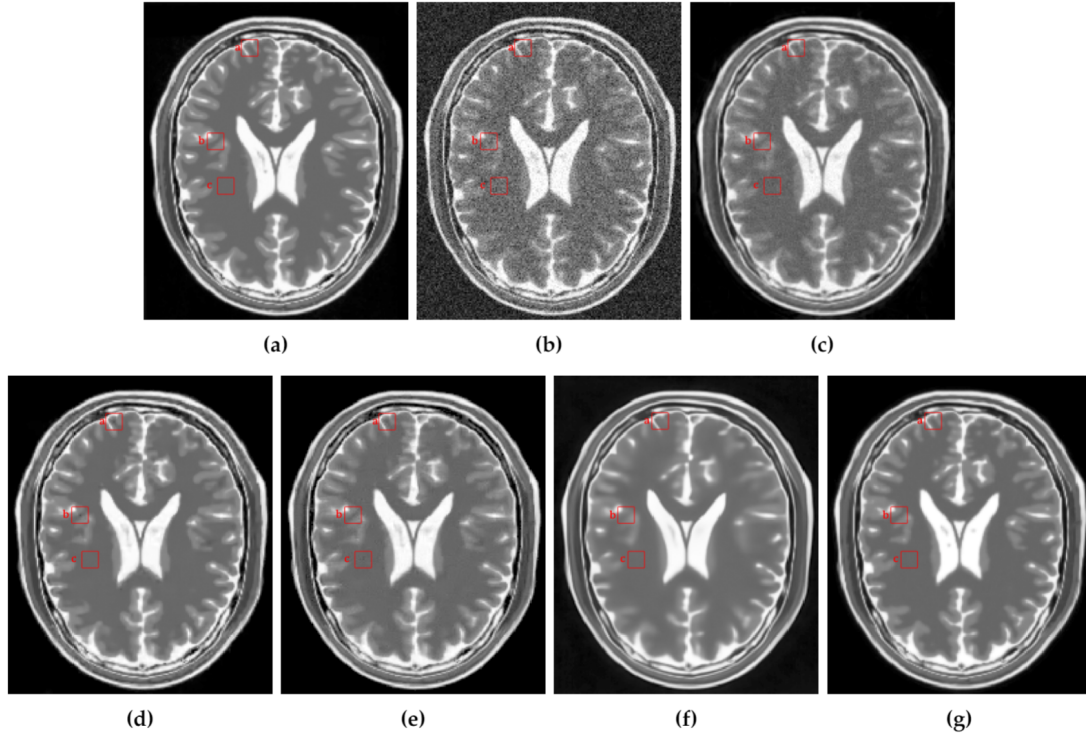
Comparison of the denoising methods on the T2w synthetic noise-free MR image corrupted with 7% Rician noise. (a) Original synthetic noise-free MR image. (b) Original image corrupted with 7% Rician noise. (c)–(g) Denoising results of the KSVD, the PRINLM, the BM4D, the DnCNN and the NLSD respectively.
